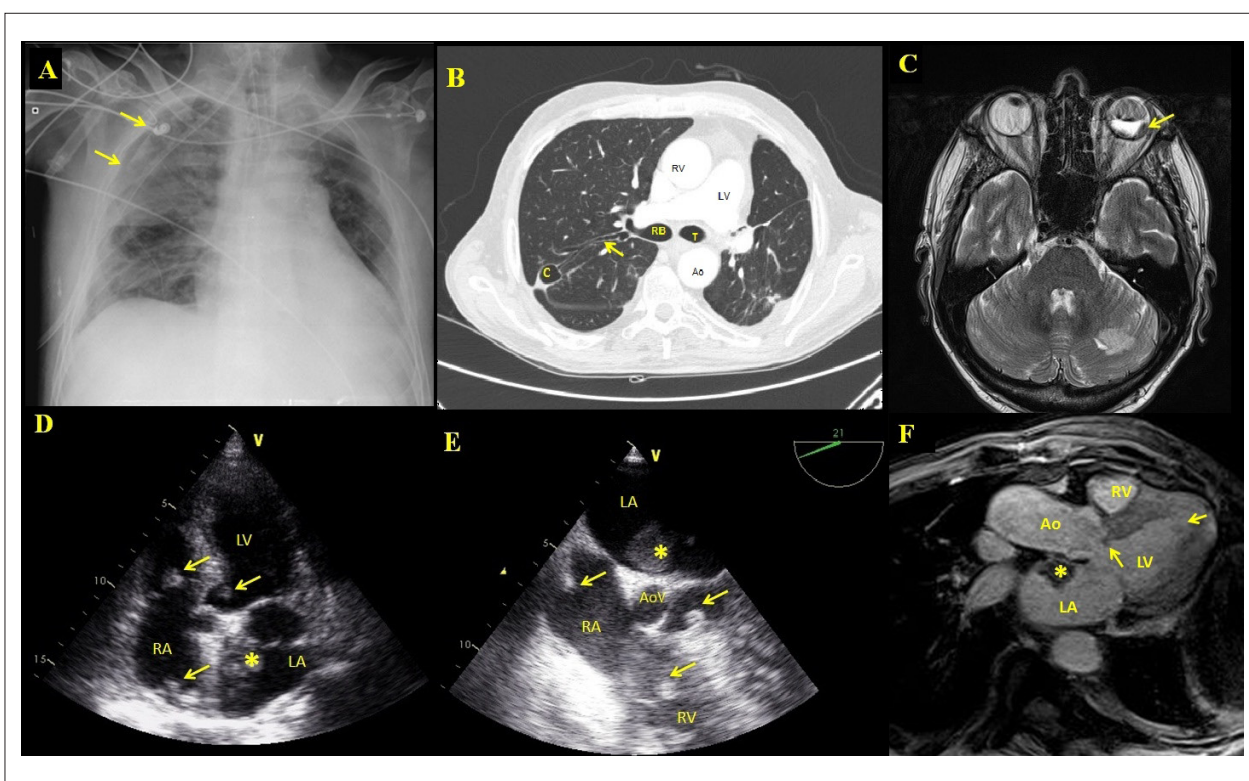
A Chest radiograph on admission showed right sided pneumothorax, evidenced by the presence of the visceral pleural white line (arrows). Left pulmonary field is atelectatic due to the previous lobectomy. B: Thoracic computer tomography showing an air-filled cavity (C) (12x20mm) in the posterior segment of the right upper pulmonary lobe that communicates with the adjacent bronchus (arrow). C: Cranial magnetic resonance showing hyperintense T1 signal in the posterior part of left eyeball (arrow), indicating fatty infiltration related to inflammatory process (endophthalmitis). D: Longitudinal five-chamber view on transthoracic echocardiogram, highlighting the presence of a heterogeneous left atrial mass (*), with no clear point of attachment to the interatrial septum. Smaller masses were also found in the left ventricular outflow tract, tricuspid valve and right atrium (arrows). E: Longitudinal five-chamber view on transesophageal echocardiogram, highlighting the presence of a heterogeneous left atrial mass (*), with no clear point of attachment to the interatrial septum. Smaller masses were also found in the left ventricular outflow tract, tricuspid valve and right atrium (arrows). F: Longitudinal three-chamber view of a cine sequence of cardiac resonance, highlighting the presence of an isointense left atrial mass (*). Smaller masses were also found in the left ventricular outflow tract and left ventricle (arrows). RV: right ventricle; LV: left ventricle; RB: right bronchus; Ao: aorta; T: trachea; LA: left atrium; RA: right atrium; RV: right ventricle; AoV: aortic Valve.
